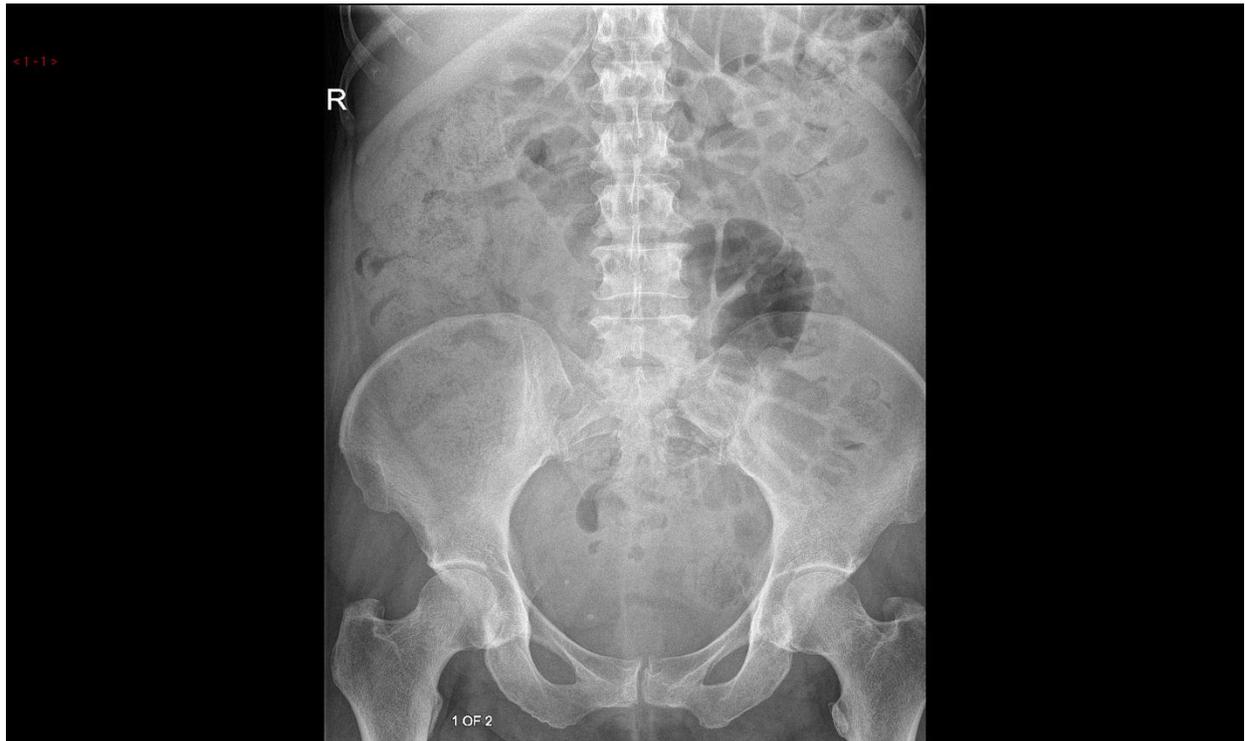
Plain film abdominal X-ray showing dilated loops of small bowel, faecal loading and no air in the rectum.
